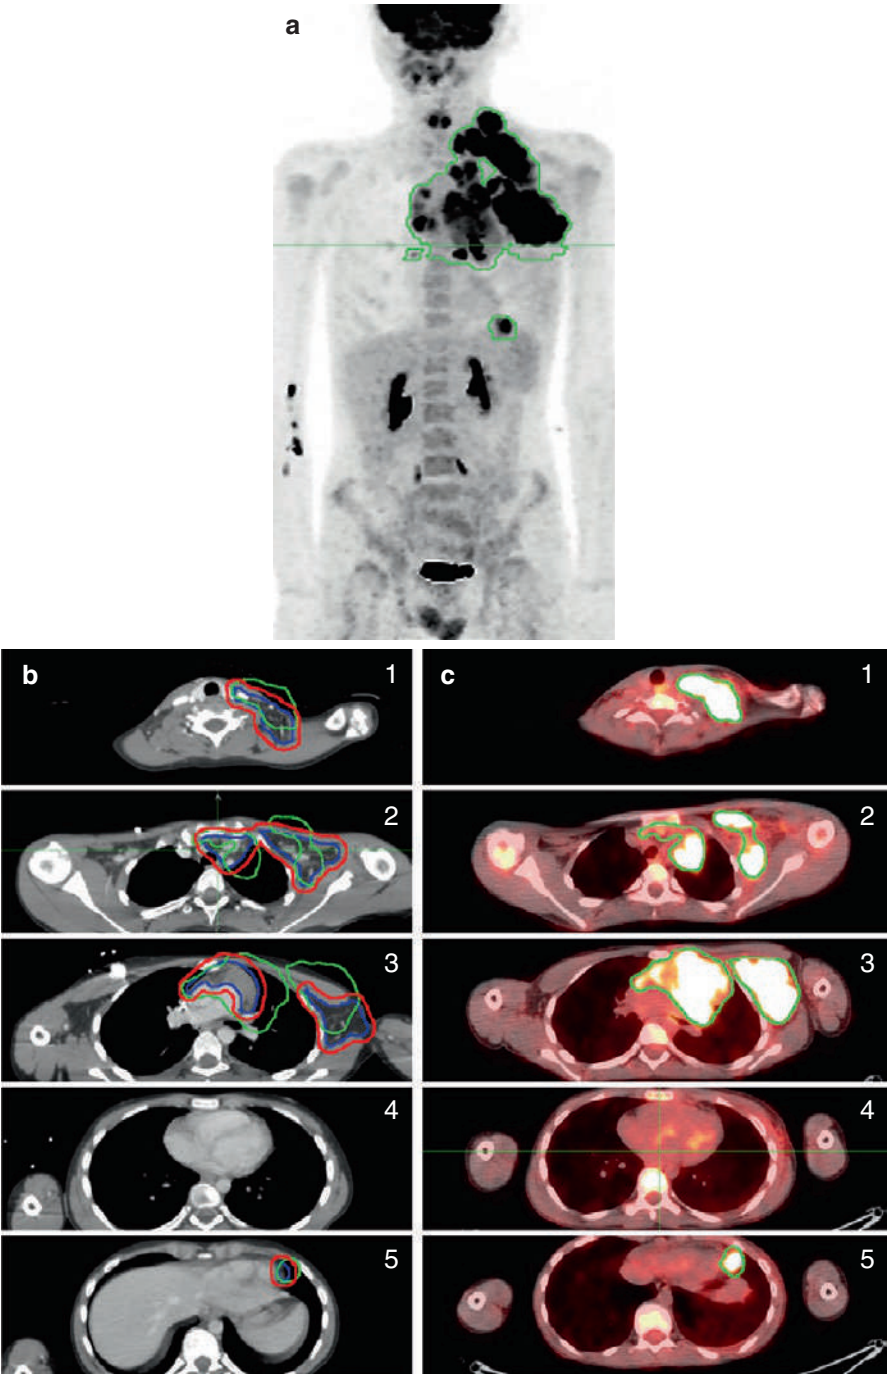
A 17-year-old boy with IIAX Hodgkin lymphoma with rapid early response on PET after two cycles of chemotherapy. (a) and (c) demonstrate pre-chemo GTV as defined by PET-CT imaging on (b, d) in green. (e) Demonstrates pre-chemo GTV (green), CTV (blue), and PTV (red)
